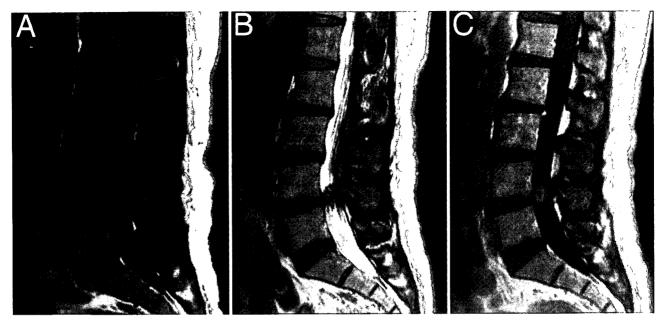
Sagittal T1-weighted (A), T2-weighted (B), and Gd-enhanced T1-weighted (C) MR images demonstrating the masses in the vertebral canal at L4–5.
